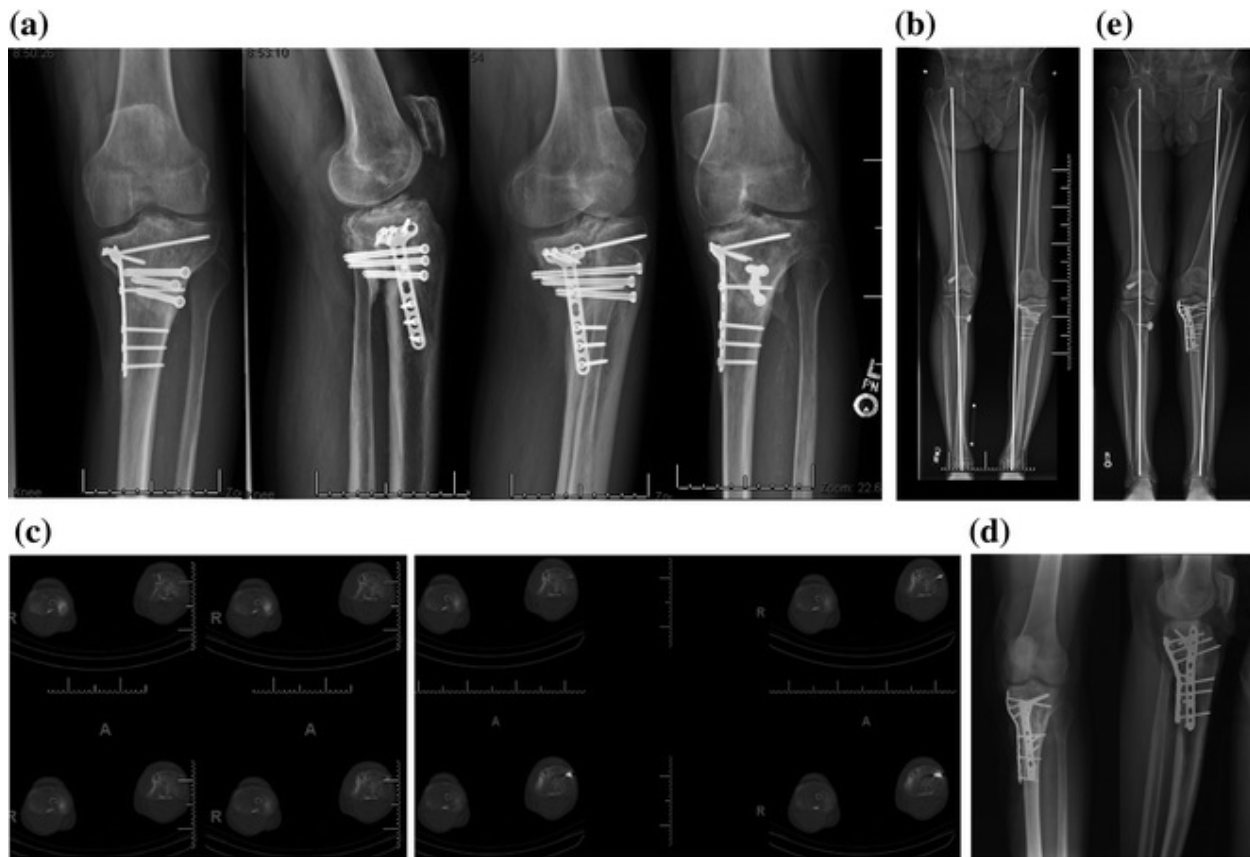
a Knee radiographs demonstrate varus deformity and apparent intra-articular nonunion. b Full-length weight-bearing view of the bilateral lower extremities confirms varus malalignment as well
